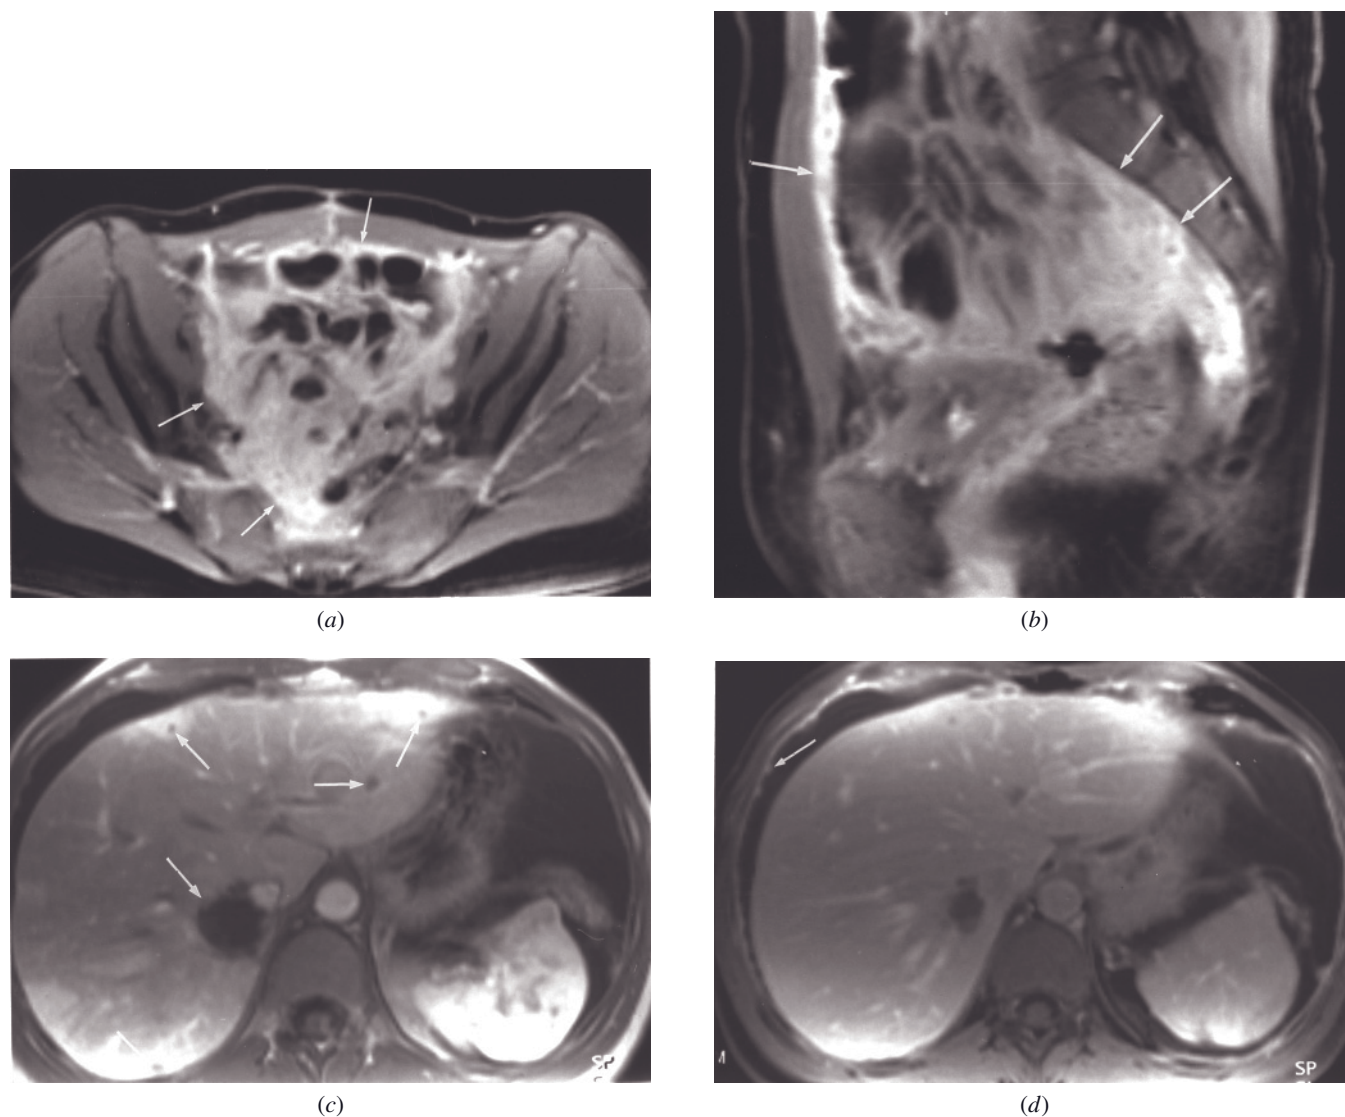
Colon cancer with peritoneal disease and hepatic metastases. Transverse (a) and sagittal (b) T2-weighted SSETSE, transverse immediate postgadolinium SGE (c), and 90-s postgadolinium fat-suppressed SGE (d) images demonstrate a large recurrent rectal carcinoma in the presacral space, with extensive local infiltration in the pelvis (arrows, a, b). Immediate postgadolinium image demonstrates the presence of hepatic metastases (arrows, c). The peritoneal involvement in the upper abdomen is well shown on interstitial-phase postcontrast image (arrow, d).
